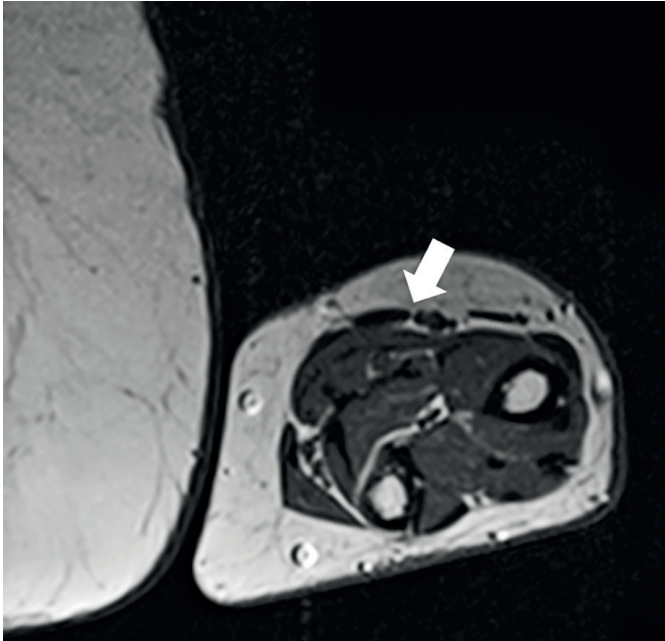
Axial MRI T1 weighted: Atrophy of forearm muscles.
